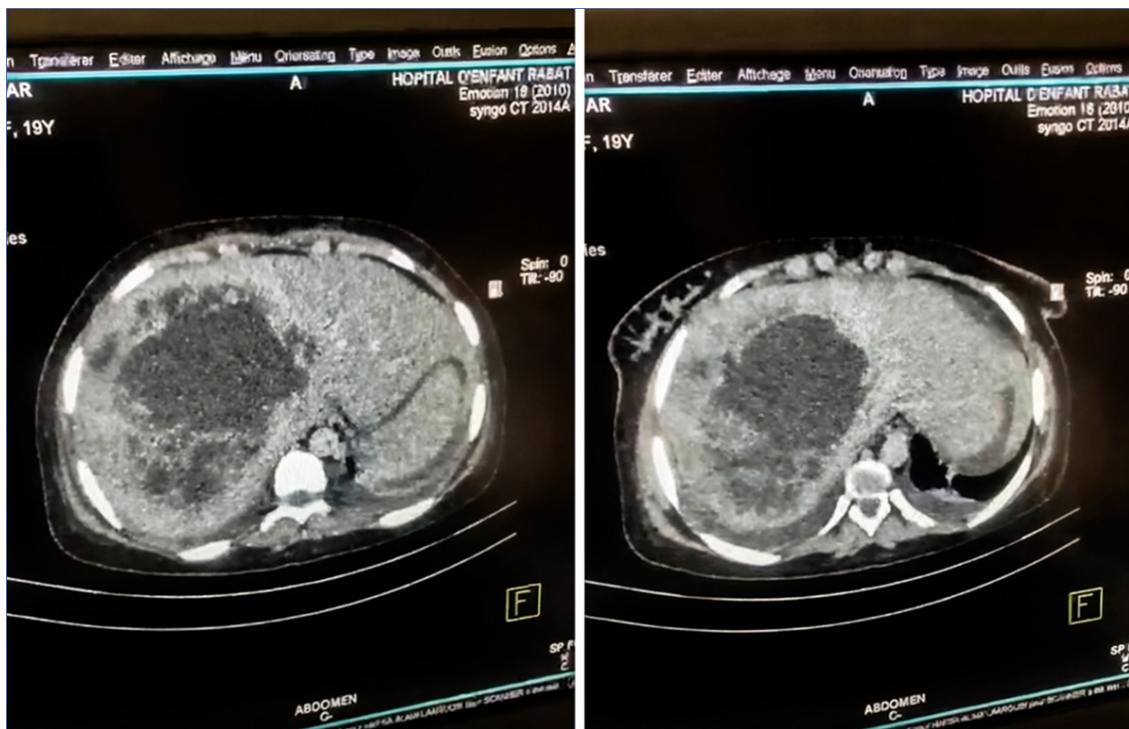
Contrast-enhanced abdominal and pelvic CT scan revealed a liver abscess.
